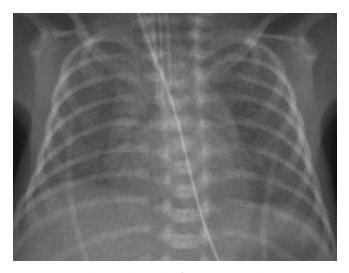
Chest radiograph of a preterm newborn with moderate respiratory distress syndrome. Note the diffuse granularity throughout the lungs and mild, central, air bronchograms. The lungs are only eight ribs expanded despite mechanical ventilation.
